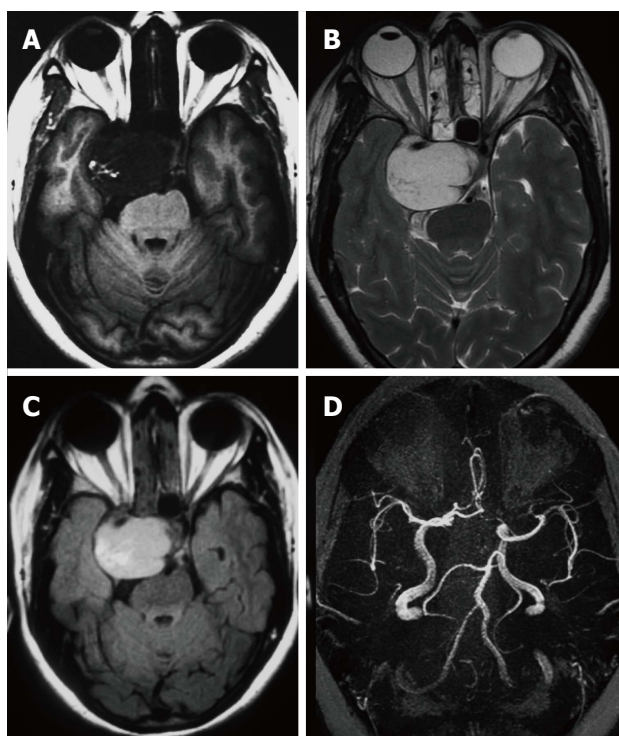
T1 weighted image, T2 weighted image and fluid-attenuated inversion recovery imaging images. A: Axial MRI image shows well defined lobulated hypointense mass on T1-W sequence image in the right cavernous sinus; B: Homogeneous hyperintensity of the mass is noted in the T2-W axial image; C: T2-W FLAIR axial image demonstrates marked hyperintense signal of the lesion; D: MRA reveals laterally stretched and displaced cavernous carotid segment. T1-W: T1 weighted image; T2-W: T2 weighted image; FLAIR: Fluid attenuated inversion recovery; MRI: Magnetic resonance imaging; MRA: Magnetic resonance angiography.
